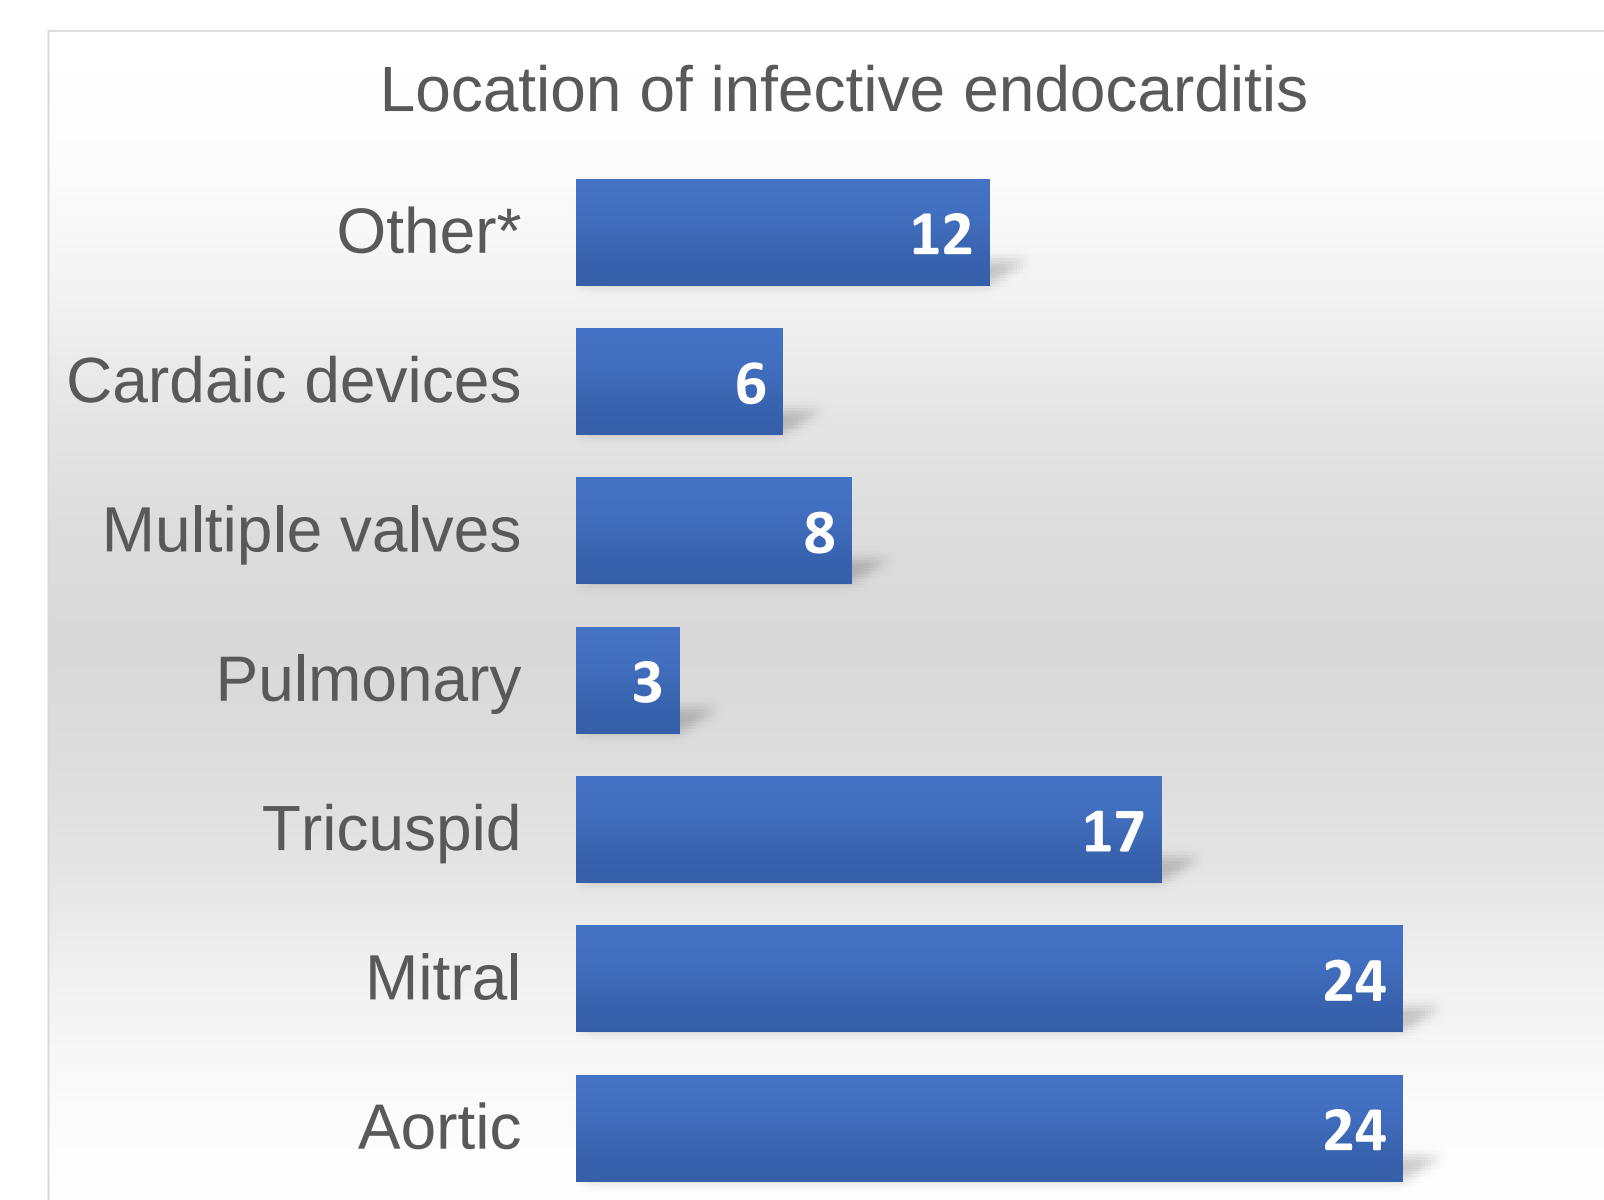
Location of IE in patients with IE confirmed on echocardiography (*includes aortic wall, muscle, cardiac transplant and unspecified sites).
